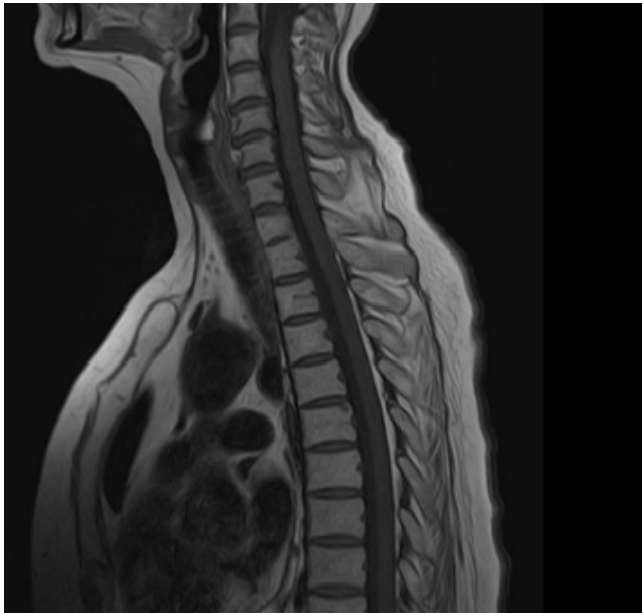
Cervical and thoracic spine MRI (T1 weighted image) showed an increase in the signal intensity in the post-contrast series in the area of meninges
